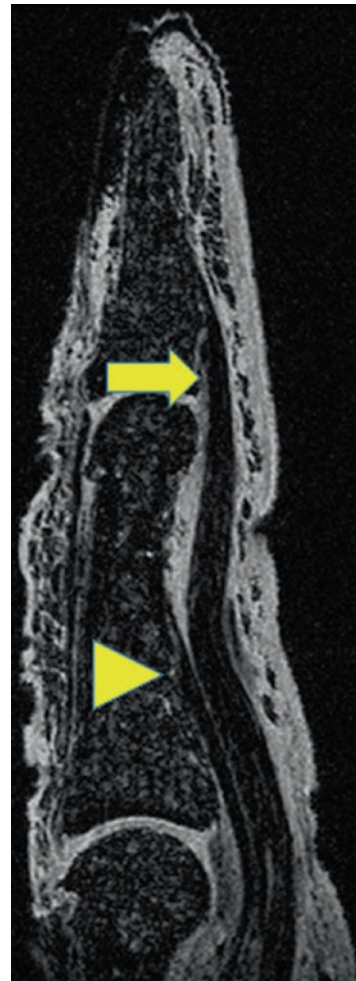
Sagittal gradient MR image showing the distal attachment sites of flexor digitorum superficialis (arrowhead) and flexor digitorum profundus (arrow)
